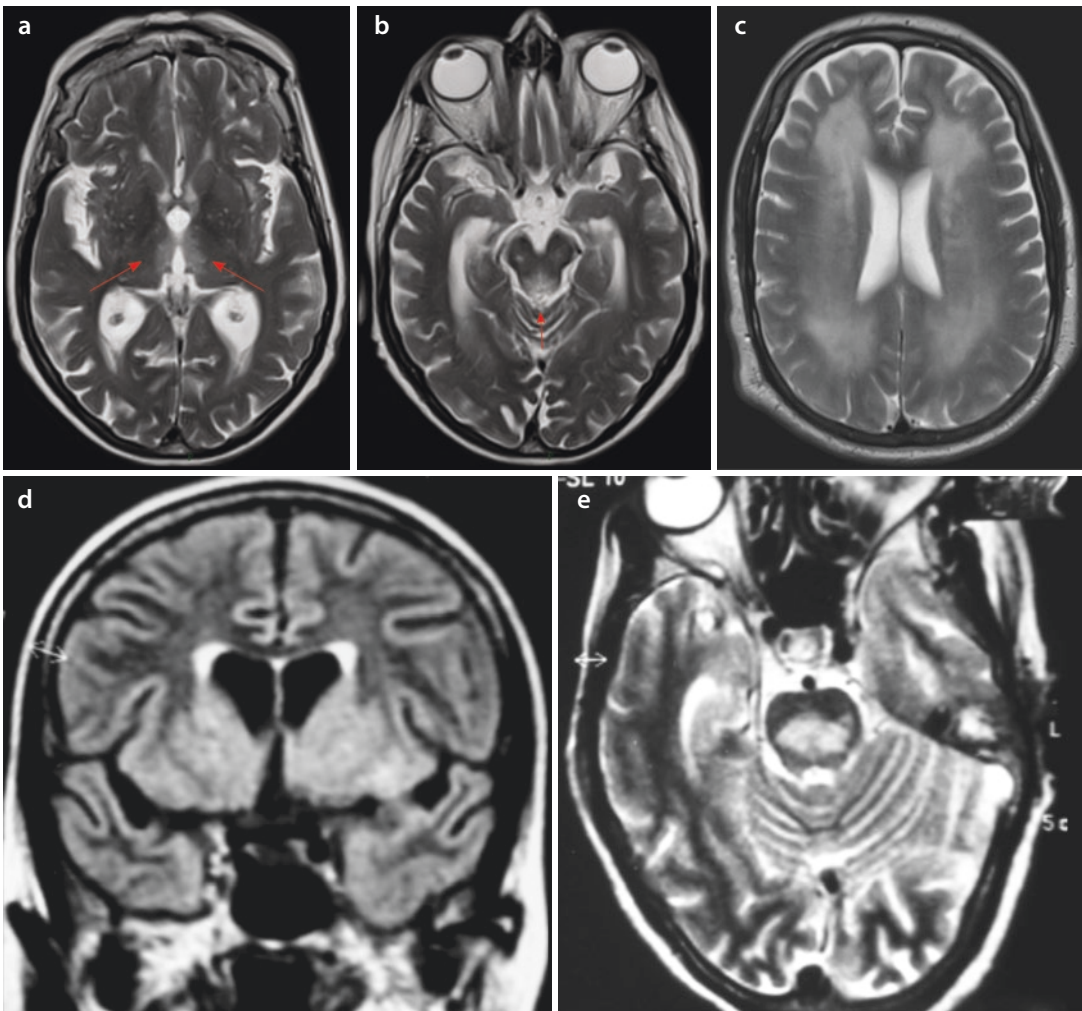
Neuroimaging of neurological complications of drug addiction. T2 MRI sequences demonstrating (a) medial thalamic and (b) dorsal midbrain signal change in Wernicke's encephalopathy. (c) Diffuse white matter
